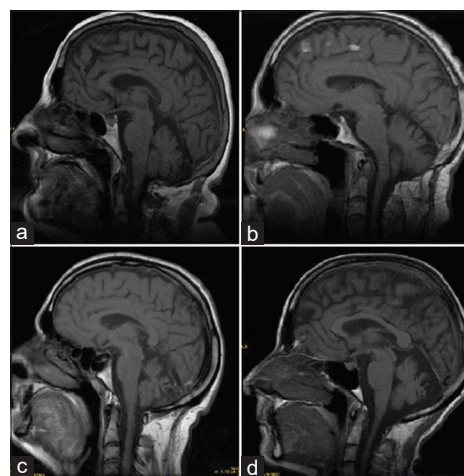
Magnetic resonance imaging study. Sagittal sections of the 4 patients (a) case I, (b) case II, (c) case III, (d) case (IV) show different degrees of atrophy of the cerebellar vermis
